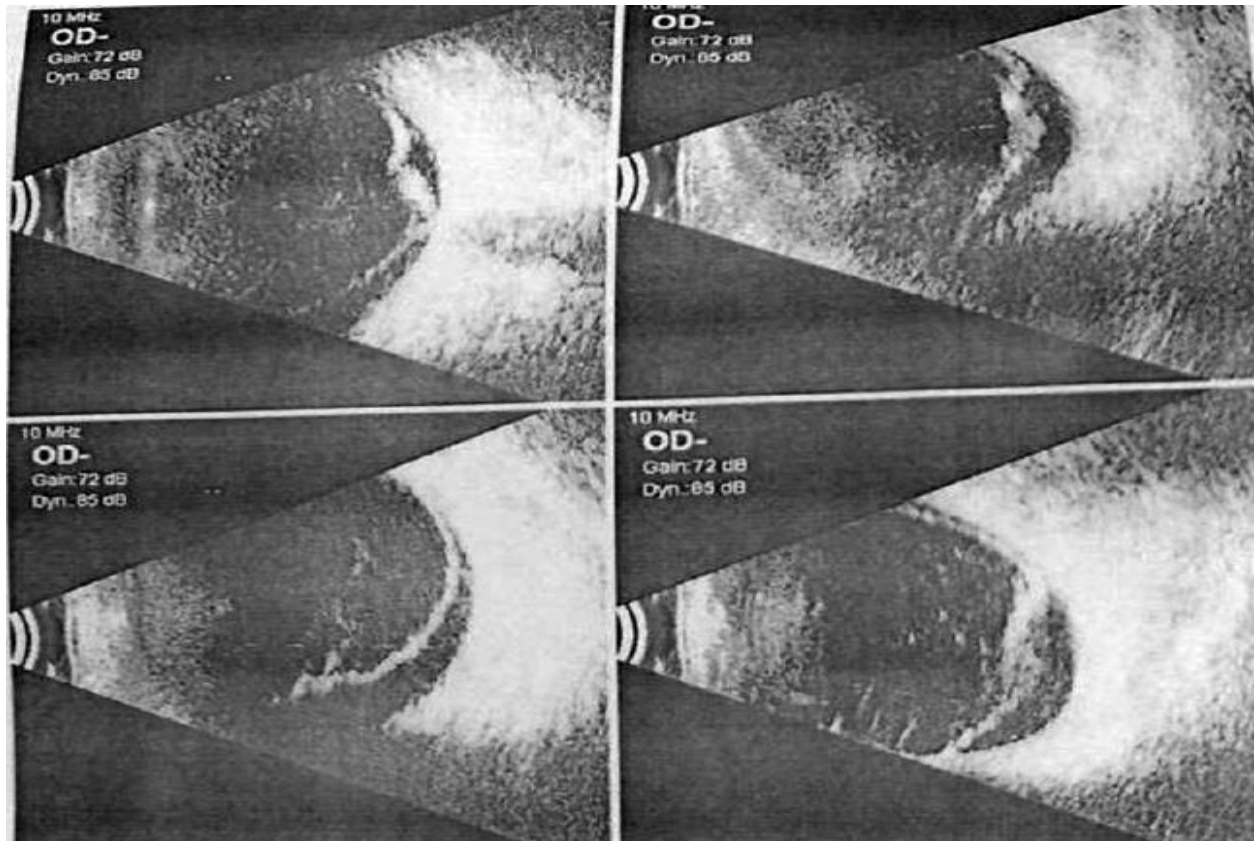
Ultrasonography B-scan showing retinal detachment⁶
